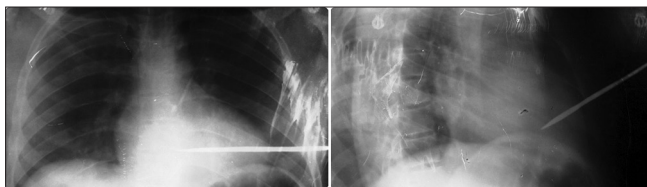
Chest X-ray showing arrow penetrating the heart
